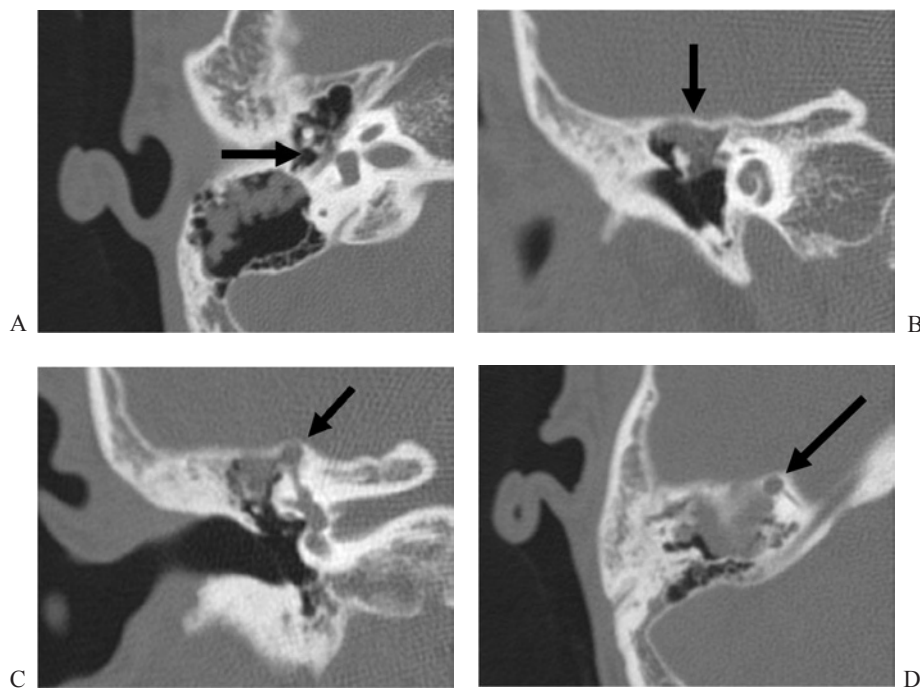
Axial section CT. A. The superstructure of the stapes was detected (arrow); B. Attic was filled with soft tissue density (arrow). Coronal and axial section CT. C, D. Part of the bone surrounding the anterior semicircular canal was unclear (arrow). The anterior semicircular canal fistula was suspected.
